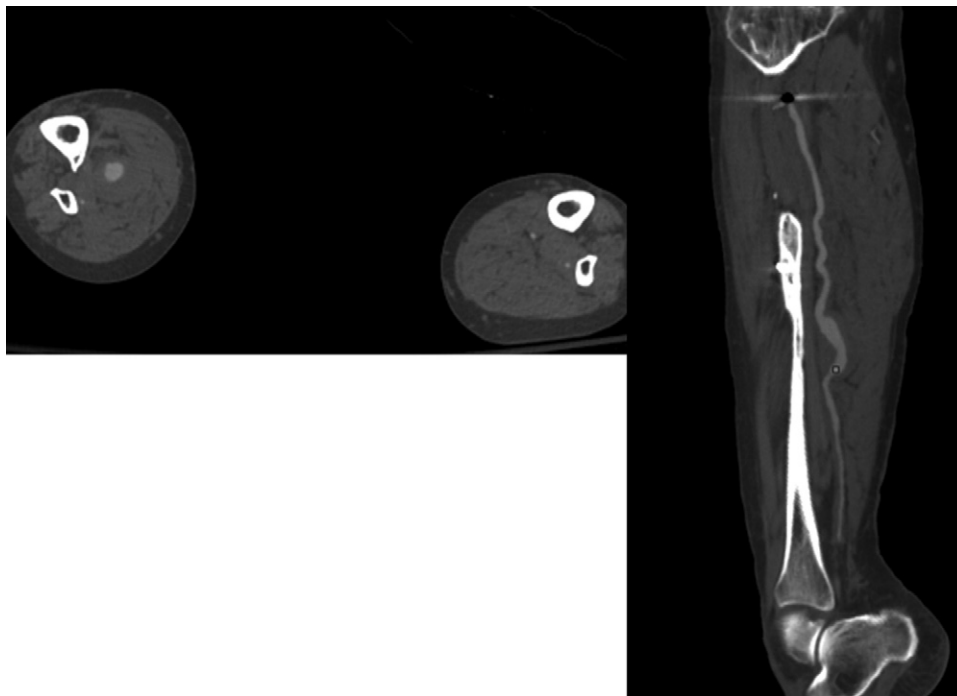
Computed tomography angiography (CTA) of left lower extremity demonstrating a 3 cm posterior tibial artery (PTA) aneurysm.
